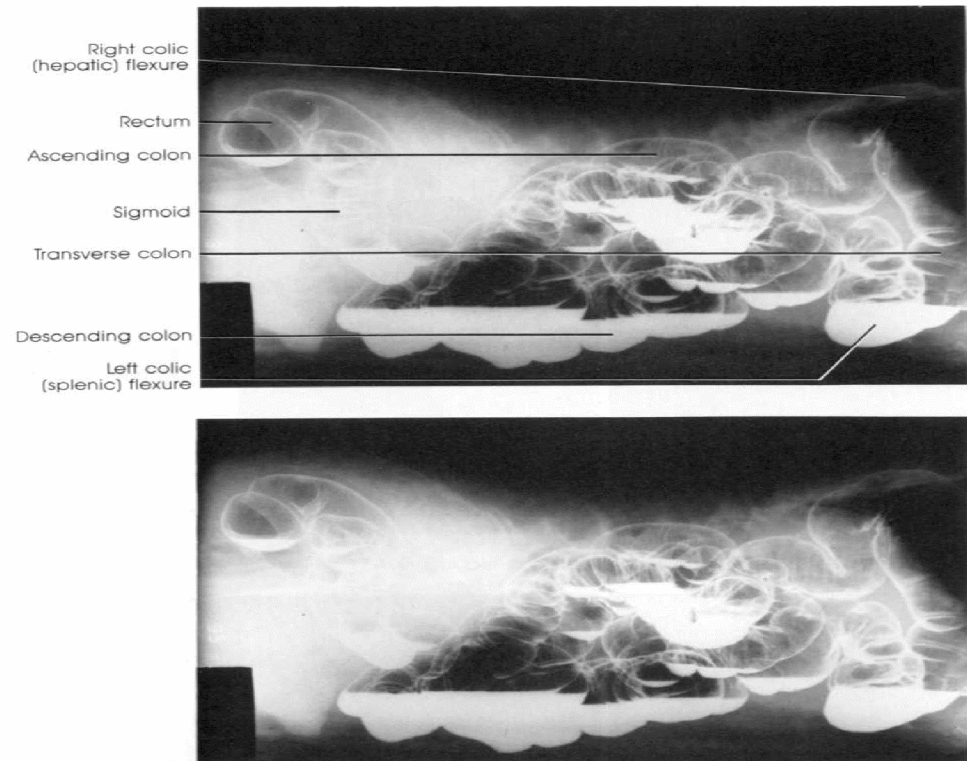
Ventral decubitus body position resulting in a lateral radiographic image.
